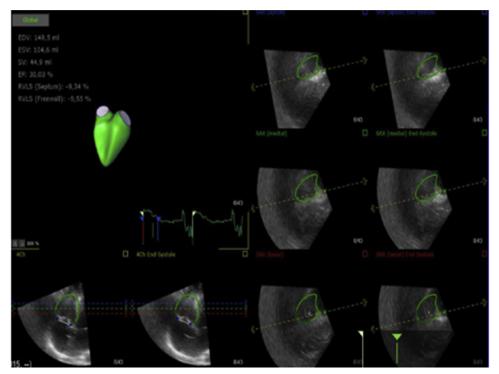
RV function by 3D echocardiography. RV 3D echocardiography in a 49-year-old patient with ChHD and HF presenting in New York Heart Association functional class III. In addition, the results for RV longitudinal strain (RVLS) by speckle-tracking are shown *(top left)*. RV end-diastolic volume (EDV) was 149.5 ml; RV end-systolic volume (ESV) was 104.6 ml; RVEF was 30%; RV stroke volume (SV) was 44.9 mL; septal RVLS was -9.34%; free wall RVLS was -9.55%.
